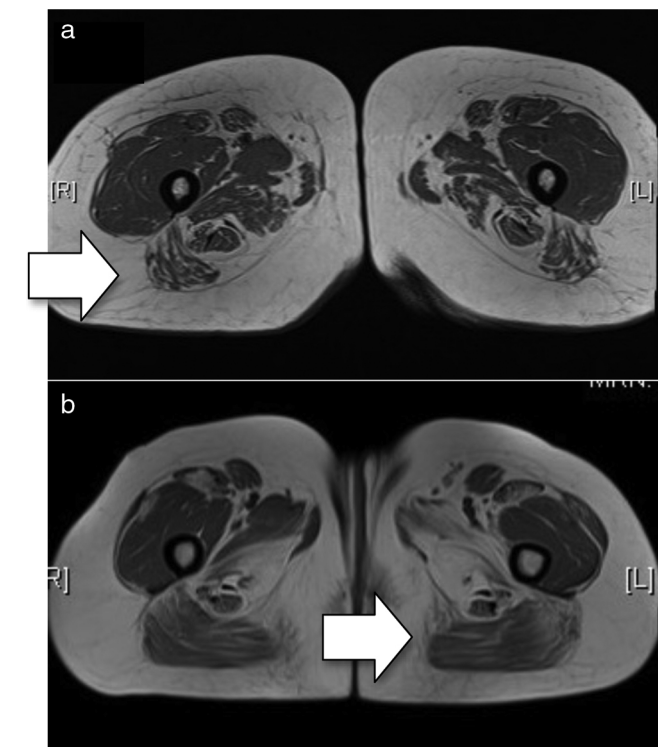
(a) Baseline MRI (T1 sequence). There is minimal oedema in the distal end of both the sartorius and gracilis muscles. Compromise of both compartments, with the lateral mass more affected in the anterior compartment and the middle masses more affected in the posterior compartment. In general, there is greater posterior compromise (arrow). (b) MRI after treatment with rituximab (T1 sequence). Bilateral and symmetrical compromise is noted of both compartments with muscular atrophy observed with diffuse fatty deposits. The lateral and middle masses are more affected in the anterior compartment and the hamstring muscles are more affected in the posterior compartment, with predominance of compromise in the posterior compartment (arrow).
